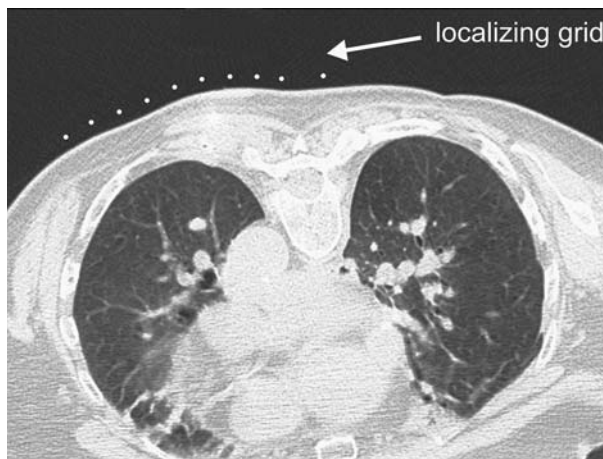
A representative CT scan showing both lungs and the localizing grid (arrow) placed over the right lung.
